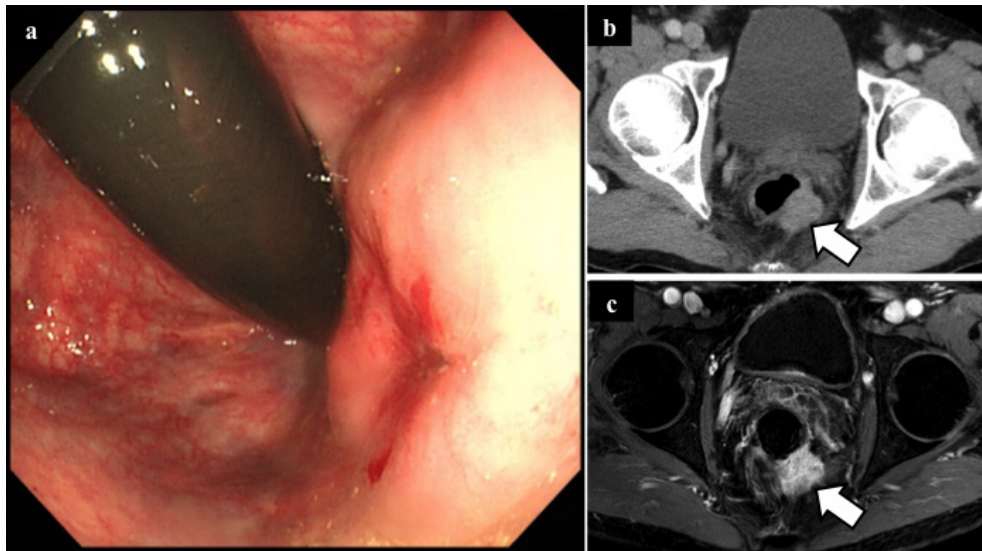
Lower gastrointestinal endoscopy, abdominal computed tomography (CT), and magnetic resonance imaging (MRI) of the rectum. Lower gastrointestinal endoscopy (a) showed a submucosal tumor with delle located 25 mm from the anal verge. Abdominal CT (b) and T2-weighted MRI (c) showed a mass (white arrow) in the left rectal wall.
